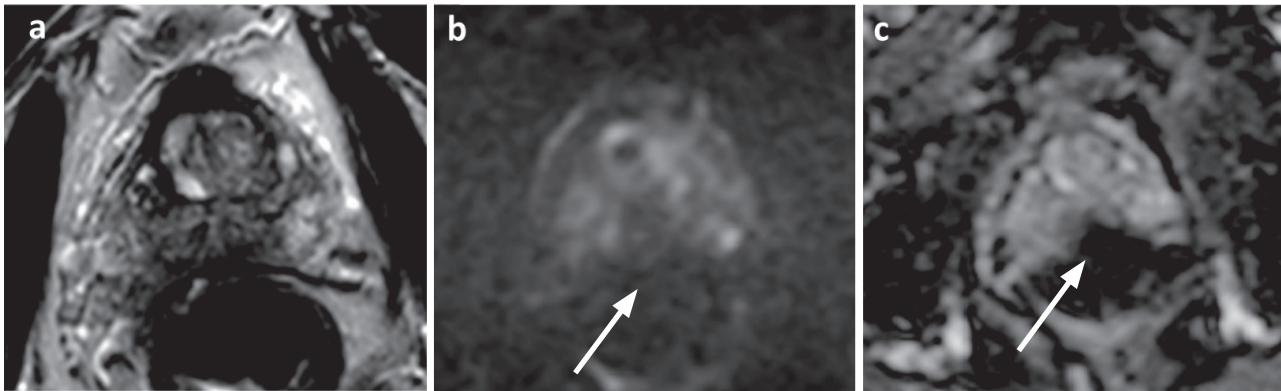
Low quality MRI. (a) T2WI with evidence of air-filled rectum. (b-c) DWI (b=1500) and ADC map with evidence of architectural distortion (arrow). T2WI, T2-weighted image; DWI, Diffusion-weighted image; ADC, Apparent diffusion coefficient.
